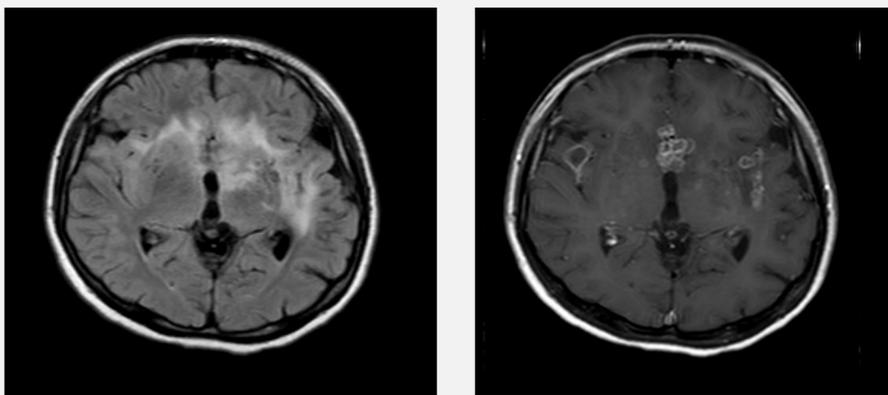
FLAIR sequence demonstrates edema in the white matter in frontal lobe, left thalamus and lentiform nucleus. There is a tiny T2-hypointense lesion in the anterior portion of the left lentiform nucleus. Contrast-enhanced T1 sequence of the same patient shows ring-enhancing lesions in the fornix, in both of the subcortical white matter of the insula and the right caudate nucleus.
